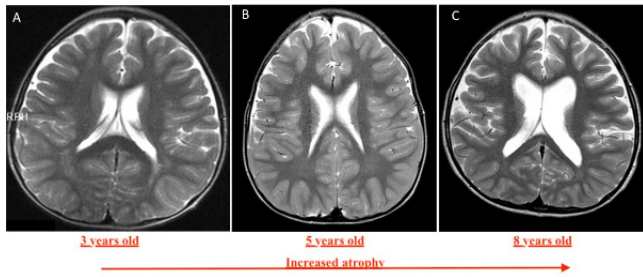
A. Cranial MR images of case III-1, at 3 years old, showing enlargement of CSF distances in the temporal lobe anterior. B. Cranial MRI images of case III-4 showing slightly increased in the frontotemporal region which could indicate to an underlying mildly cerebral atrophy (at 5 years old) C. Cranial MRI images of case III-5 showing significant general atrophy especially in frontotemporal region and dilated lateral ventricles (at 8 years old).
